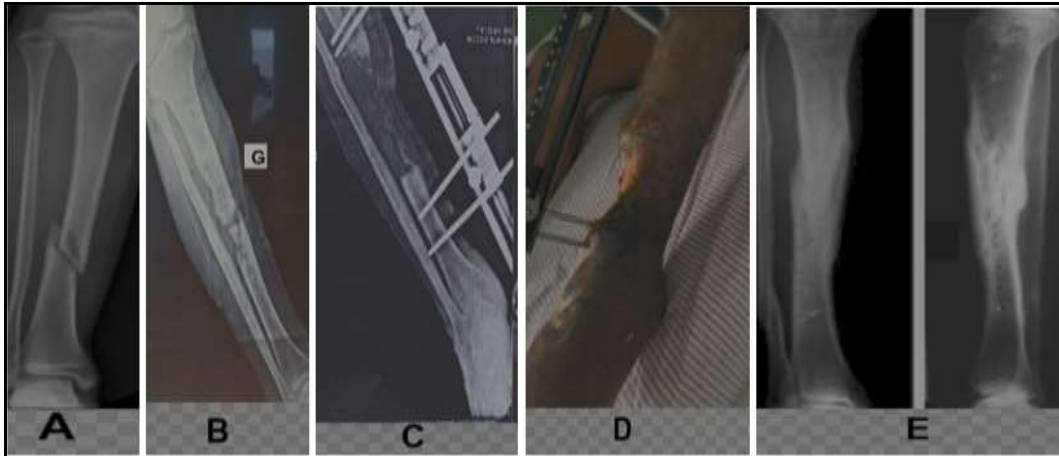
a 28-year-old man with septic pseudarthrosis of the left leg. A: initial radiograph of the left tibia, frontal view. B: left leg radiograph at the time of diagnosis of septic pseudarthrosis, frontal view. C: 1st stage of Papineau. D: 2nd stage of Papineau. E: bone consolidation.
